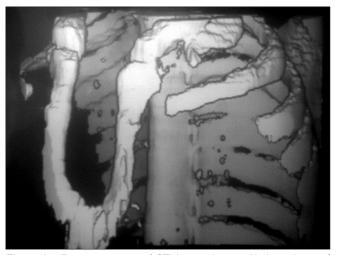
3D reconstruction of CT thorax showing U-shaped gap of the sternum
